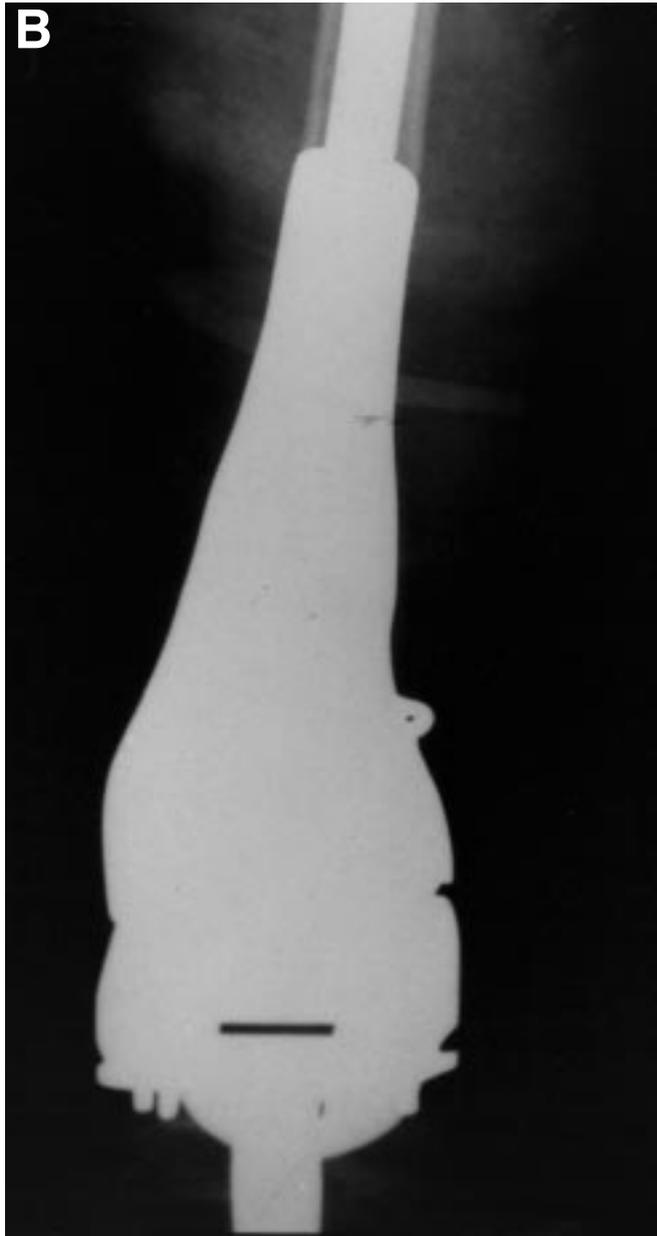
Photographs of the first distal femoral replacement performed in the United States by Dr Kenneth Francis at New York University in 1973. (A) Plain radiograph of a large Stage IIB osteosarcoma. This patient was treated with Adriamycin alone, which was the only available active sarcoma drug at that time. (B) Anterior-posterior photograph of the distal femoral replacement utilized. Note the long femoral and tibial stems. Polymethylmethacrylate was utilized for fixation. The knee component was a modified Walldius fixed knee hinge. (C) Lateral photograph of the same prosthesis. Note the long tibial stem and spikes for fixation.
